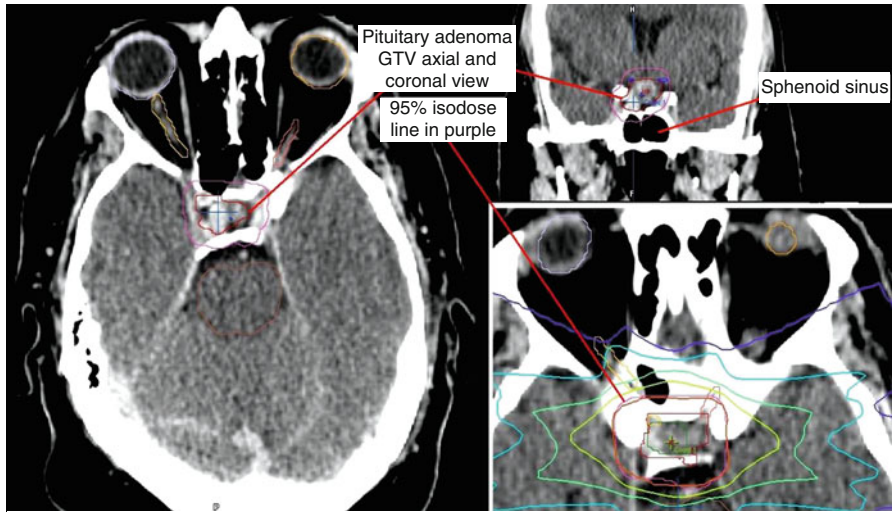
Pituitary adenoma (axial and coronal CT views), with 95 % isodose line conformally covering the PTV
